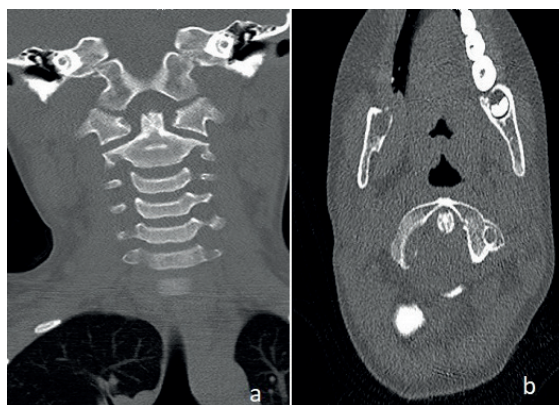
It is observed that there are no subluxation and the ordinary atlanto-axial joint distance is normal in the cervical CT images in coronal (a) axial (b) sections.
